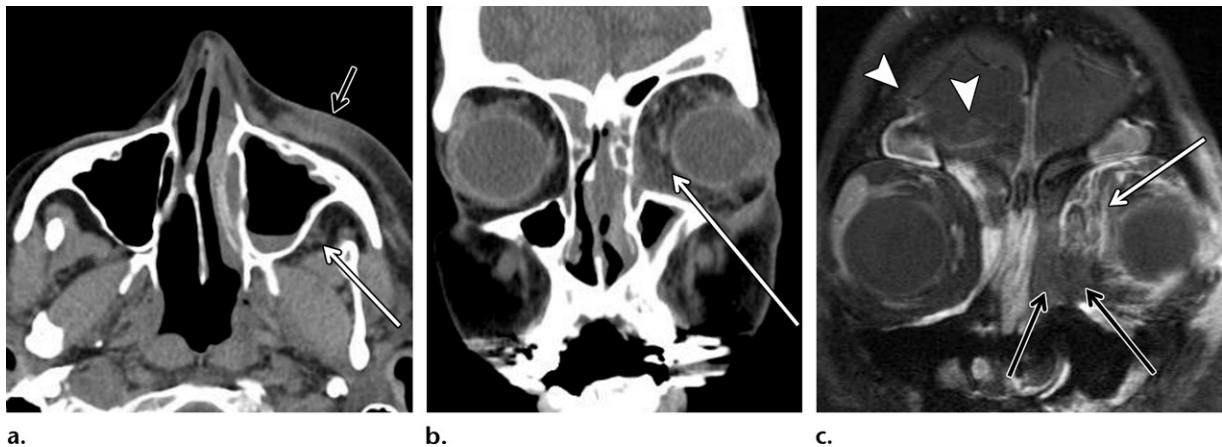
Invasive fungal sinusitis in a 62-year-old man with neutropenia after bone marrow transplant who presented with sinus disease, eye pain, and periorbital swelling and ecchymosis. (a, b) Initial axial (a) and coronal (b) CT images show a small air-fluid level in the left maxillary sinus and opacification of the ethmoid air cells and frontal sinuses with mild premaxillary (black arrow in a), retromaxillary (white arrow in a), and orbital (arrow in b) fat stranding. (c) Contrast-enhanced fat-suppressed T1-weighted MR image from follow-up examination performed 24 hours after initial CT shows marked worsening of the orbital soft-tissue inflammation (white arrow), intracranial extension with meningeal enhancement (arrowheads), and extensive necrosis (black arrows), indicated by lack of contrast enhancement along the medial orbit and lateral wall of the left nasal cavity.
